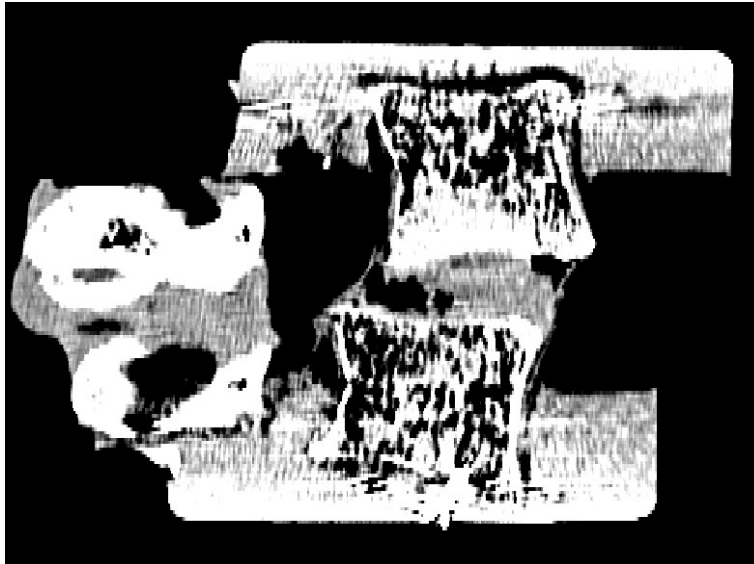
CT scan displaying successful fixation (FSU 3021 L4-L5).
